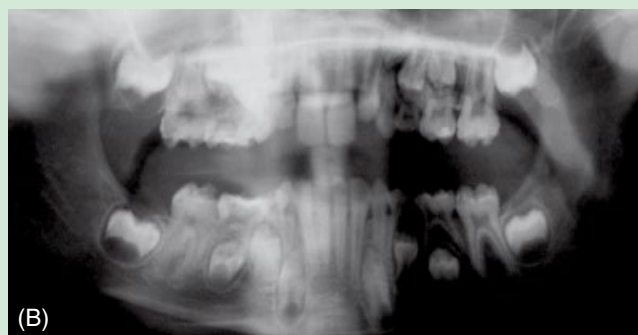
Severe enamel hypoplasia in a young patient with poor oral hygiene (A). Orthopantomograph (B).
